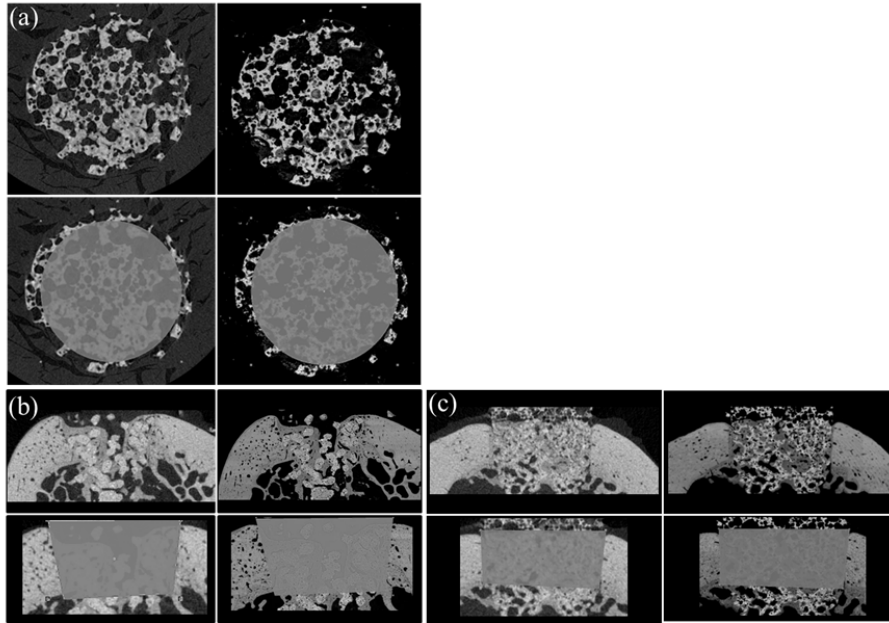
The placement of the ROIs for one IM foamed (a), one IO robocast (b) and one IO foamed (c) sample. In the upper row μ CT (left) and corresponding SEM (right) image are shown for each sample. In the lower row for the IM sample a circular ROI is shown in gray. In the IO samples a polygonal ROI is shown in gray.
